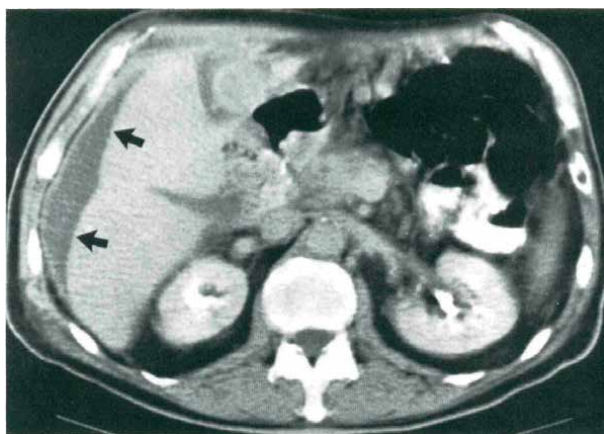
Computed tomography scan demonstrating a post-traumatic fluid collection. At this level of the scan, this may represent a subcapsular hematoma, biloma, or abscess [3].
